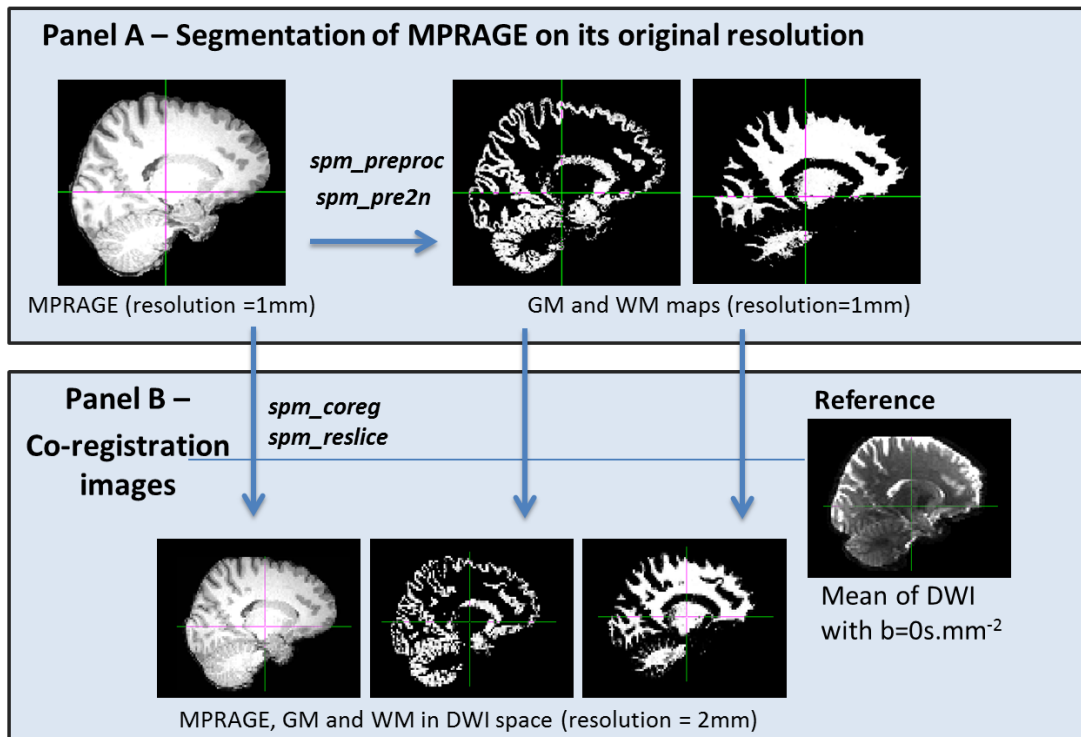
Example of the two steps to compute grey and white matter maps for one Cam-CAN subject: first the grey and white matter maps are obtained by segmentation of MPRAGE images with resolution of 1mm (panel A); secondly images are moved to DWI space by co-registration using as reference volume the mean of DWIs acquired with b-value of  $0 \text{ s.mm}^{-2}$  (panel B).
